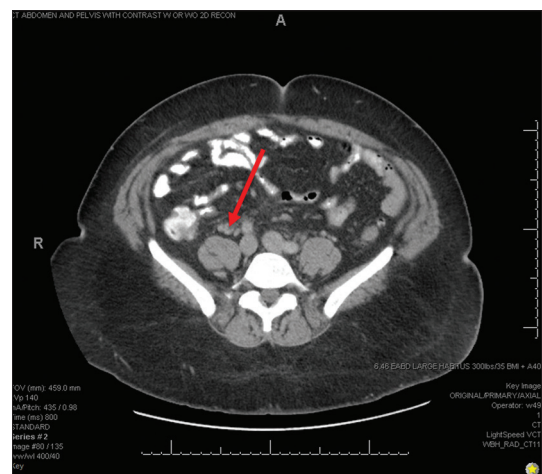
Pelvic computed tomography with intravenous contrast demonstrating a nonocclusive thrombus in the right gonadal vein (see arrow)
